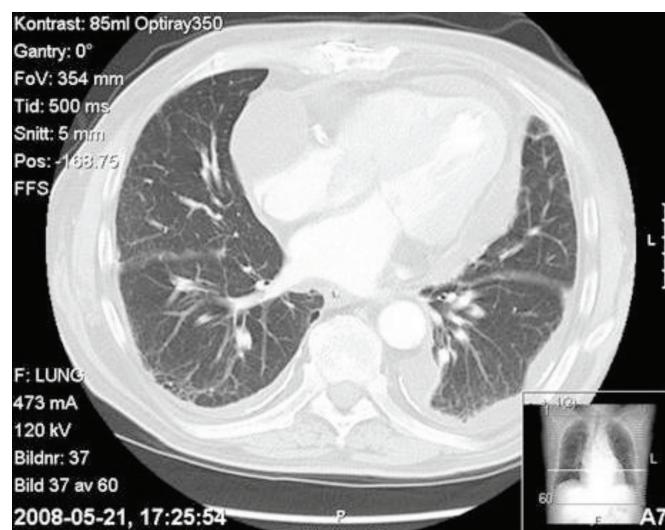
Computed tomography scan revealing a large pericardial effusion causing cardiac tamponade.
